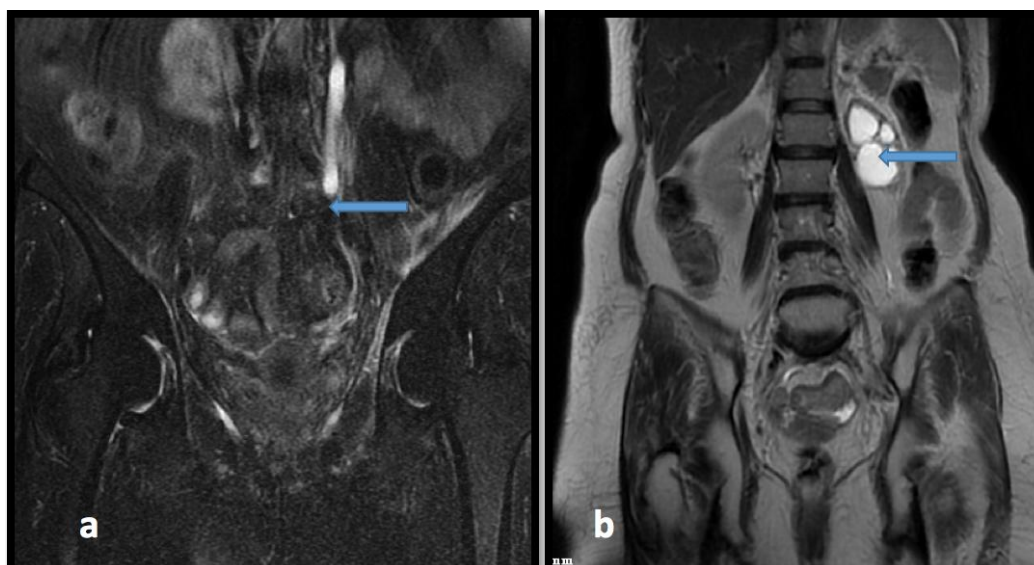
4 A case of Post Radiotherapy Fibrosis. MRI COR T2WI (a) showing soft tissue along the left pre and paravertebral region at the level of L5 vertebral body extending within the left psoas muscle with encasement of lower end of visualized Left Ureter. MRI COR FIESTA (b) showing resultant upstream dilation of Left Ureter extending up to Left pelvicalyceal system, likely to represent Post Radiotherapy Fibrosis.
